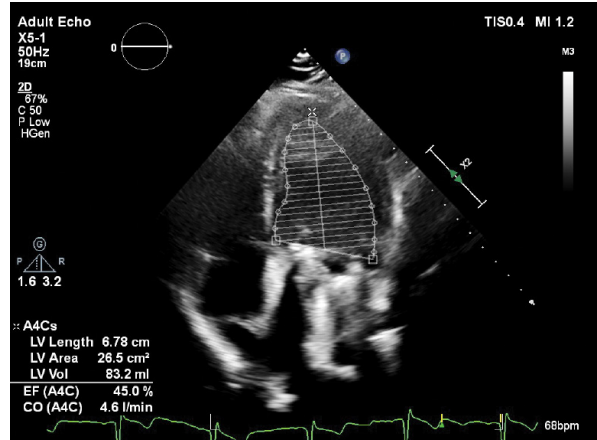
Echocardiography of left ventricular function using Simpson's volumetric method. Reduced ejection fraction (EF = 45%, Z-score: -2.92; according to Yao et al., 2019⁽¹⁰⁾)
